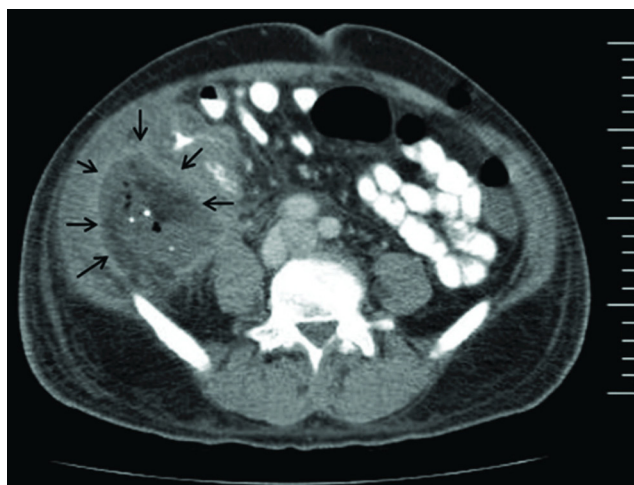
Computed tomography image of abdomen, showing large complex fluid collection (arrows).
